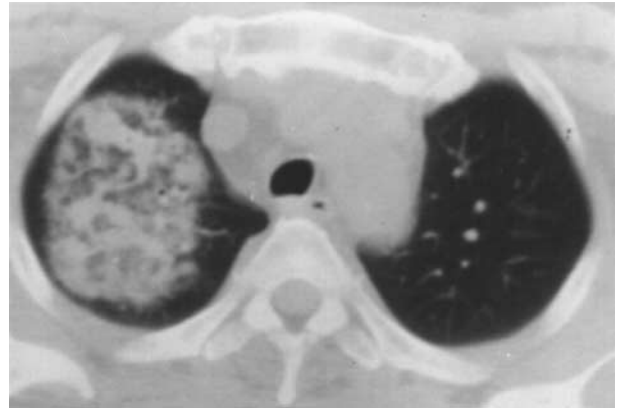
CT Image of the Chest, Showing a Right-Upper-Lobe Ground-Glass and Air-Space Opacity Involving the Central Lung Zone.
